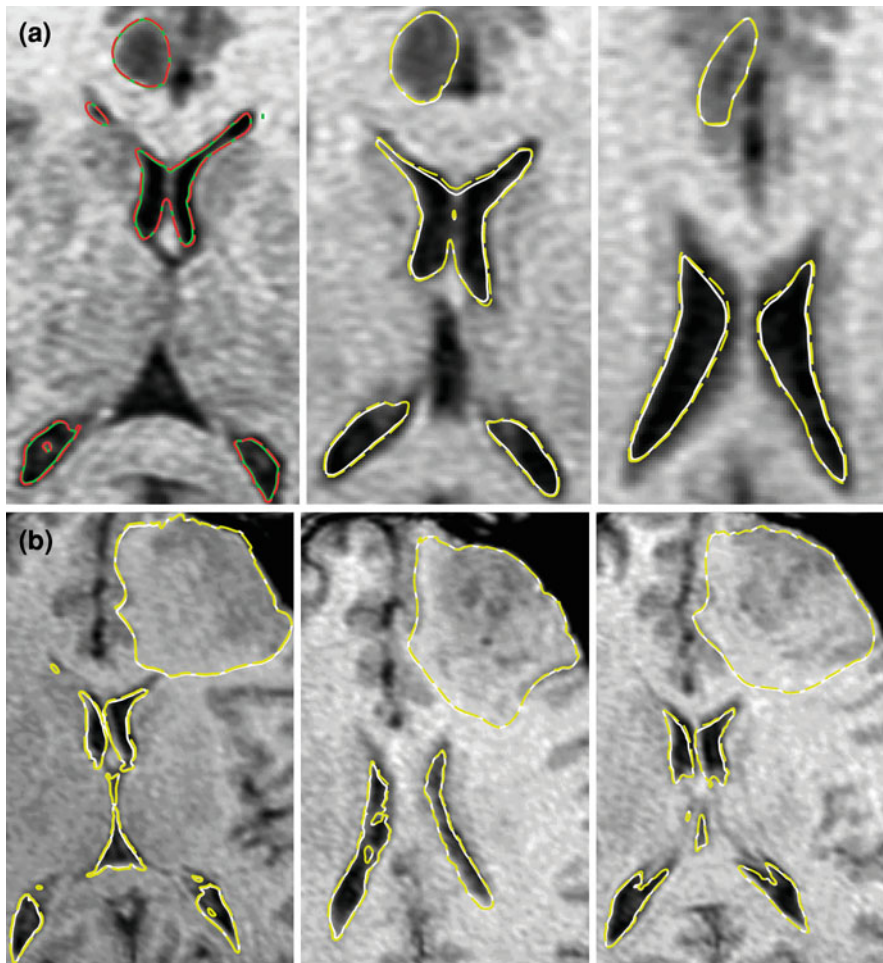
Transverse contour sections of the tumour and ventricles in Case 1(a) and 2(b), computed using the complete model (Model A, *White*) and homogenous one (Model C, *Yellow dash line*) are imposed on the intra-operative MR images. The sections are enlarged and cropped to highlight the pathology. To ensure that the sections are not subject to the choice of the authors, we used the following approach. The first sections are manually selected so both the tumour and ventricles are clearly visible; then we show sections of the 10th and 20th slices after the first one
